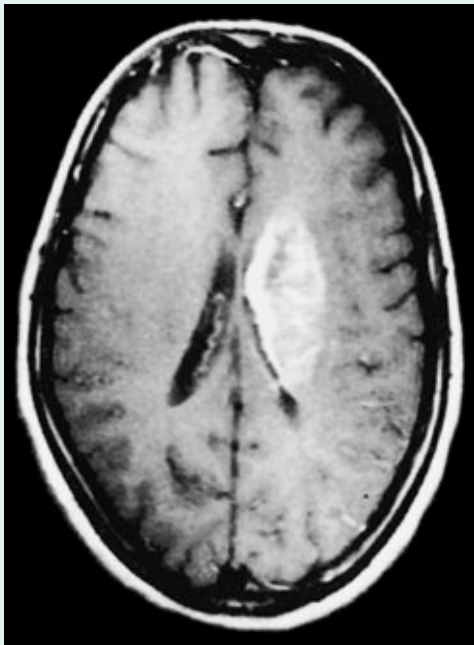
Contrast-enhanced magnetic resonance image taken from a patient 11 days after an embolic stroke (see text). (From Sato A, et al: *Radiology* 178:433–439, 1991, with kind permission of Dr S. Takahashi, Department of Radiology, Tohoku University School of Medicine, Sendai, Japan, and the editors of *Radiology*.)
